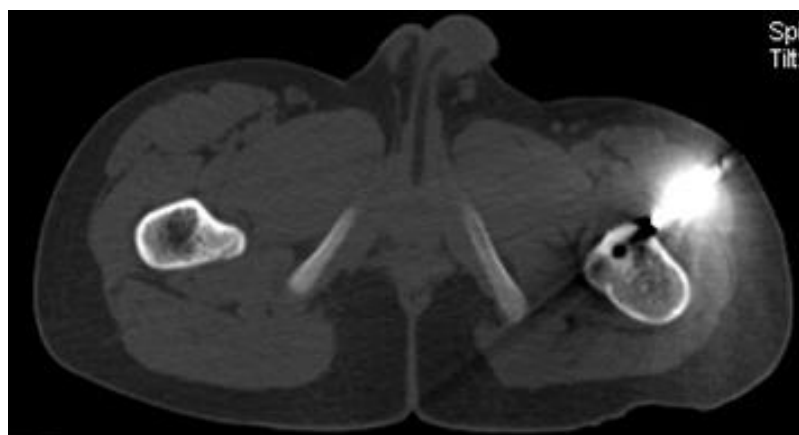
Case 2 Male, 14 years old, osteoid osteoma of proximal femur, 2014-9-2, intraoperative CT localization
